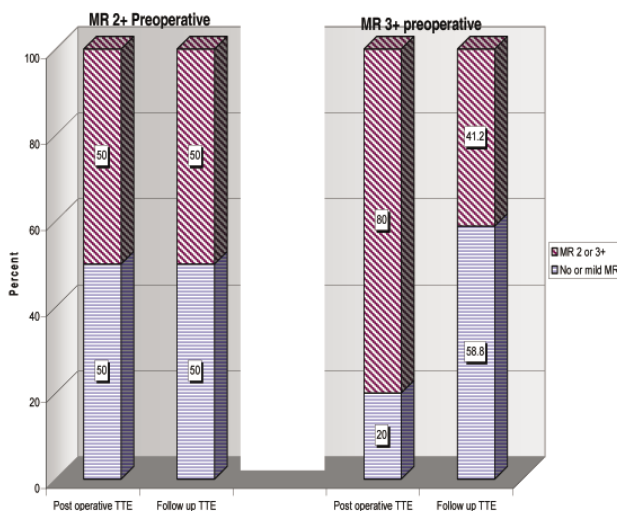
Comparison of resolution of MR in postoperative and Follow up echocardiography
